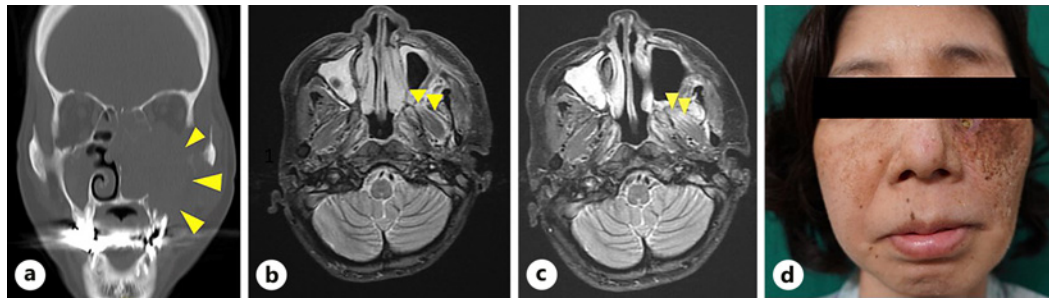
a Plain CT prior to treatment. A peripheral bone fracture image was observed in the left maxillary sinus, as shown by yellow arrowheads. b MRI following 2 months of treatment. A high signal intensity area was observed in the left lateral pterygoid muscle, as indicated by yellow arrowheads. c MRI following 4 months of treatment. There was an increase in the high signal intensity area of the left lateral pterygoid muscle, as shown by yellow arrowheads. d A skin ulceration with bone exposure was observed on the left cheek around 5 months after treatment.
